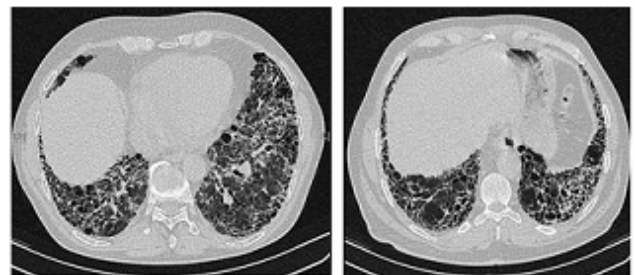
High-resolution computed tomography scans of the chest of a patient with IPF. The main features are of a peripheral, predominantly basal pattern of coarse reticulation with honeycombing.
